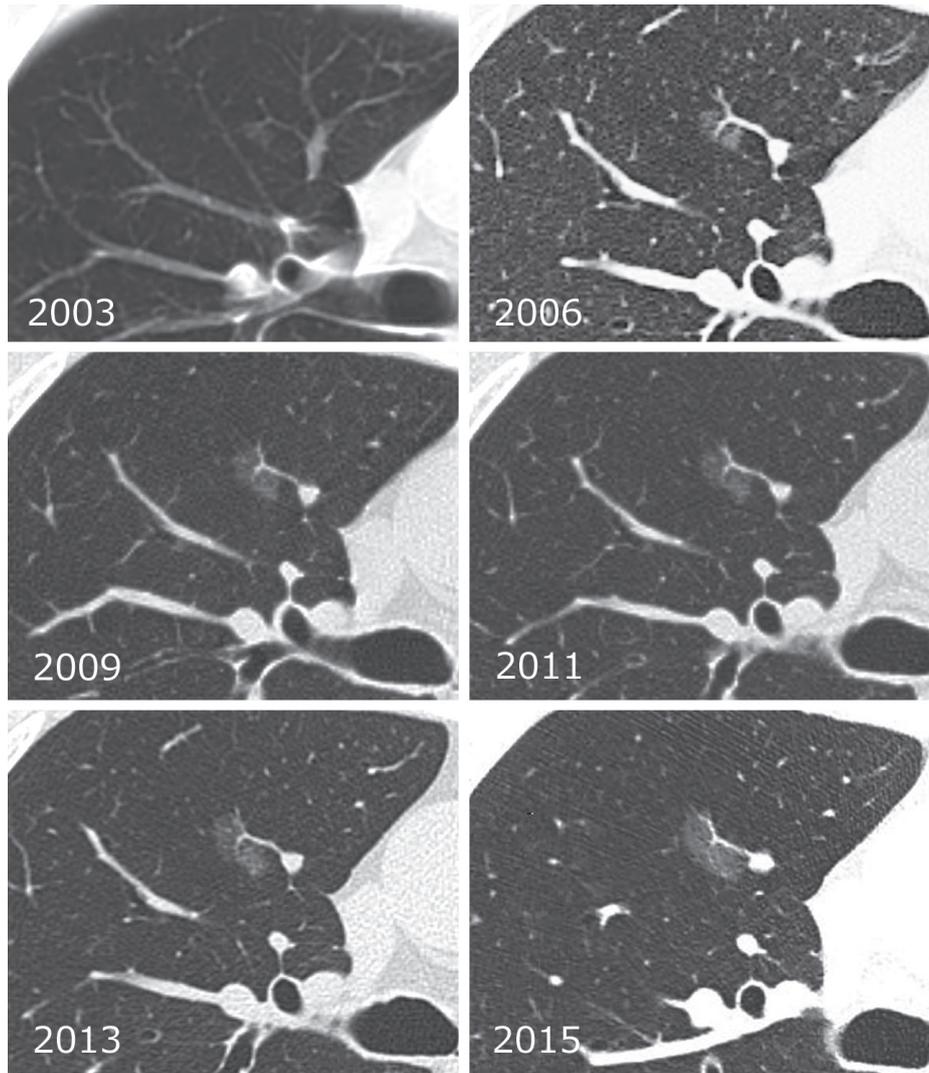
Annual Changes in CT Findings in Case 2
